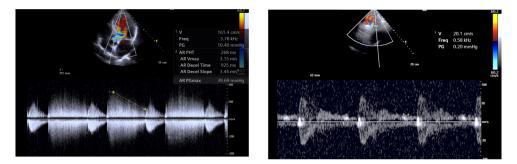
b.22. Parameters that estimated a severe aortic regurgitation in the presented case (left: CW Doppler, 5-chambers view showing a calculated PHT of 161 ms; right: PW Doppler, suprasternal view showing a maximum telediastolic velocity of 20.1 cm/s)
